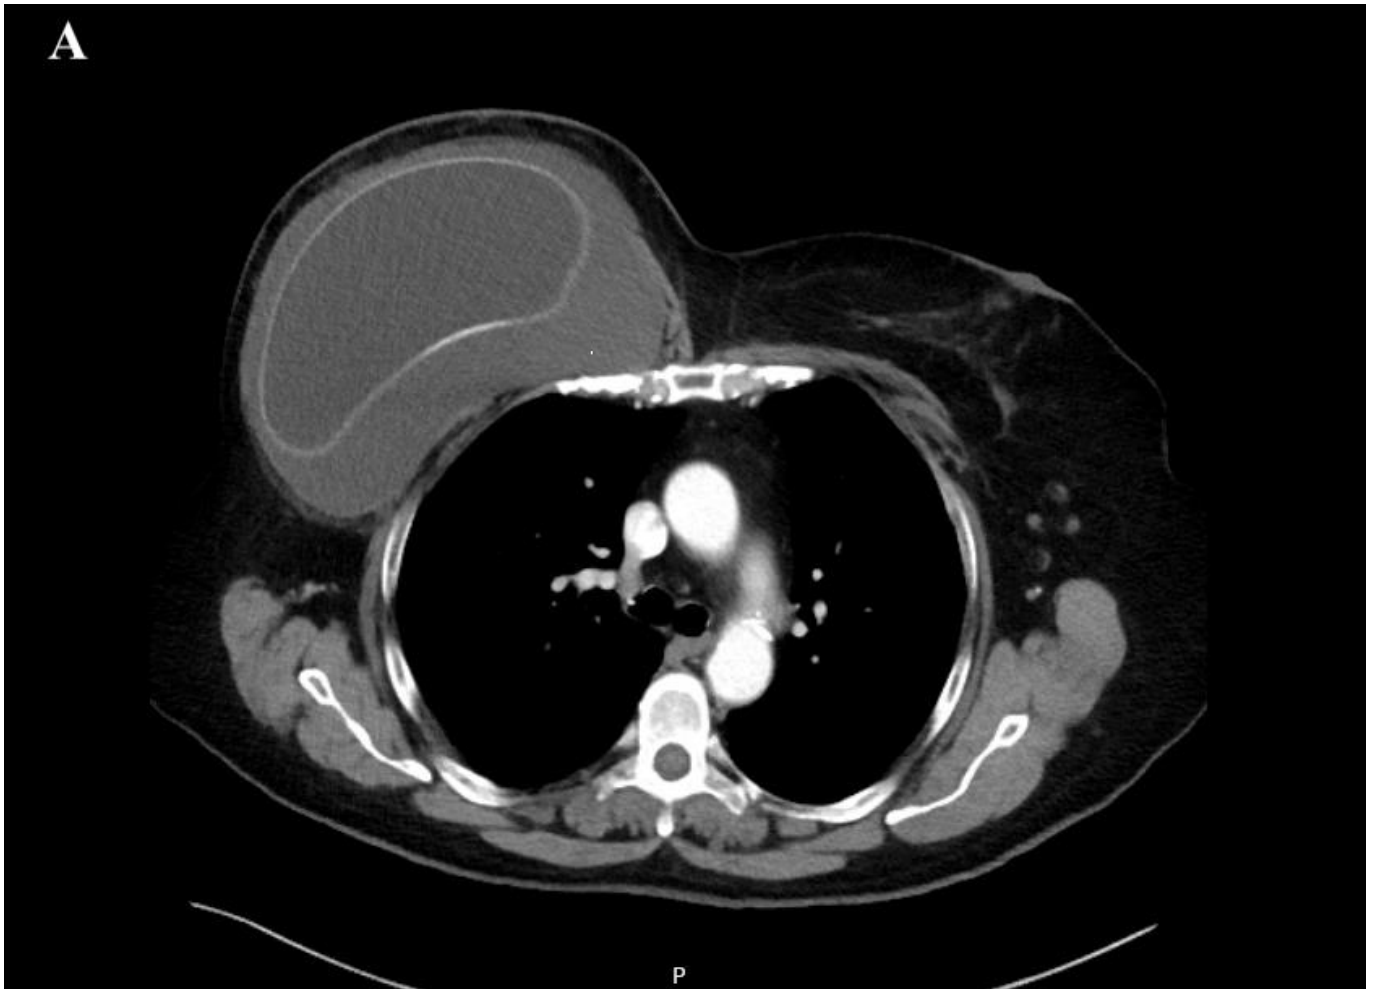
Computed tomography scan with peri-implant fluid.
